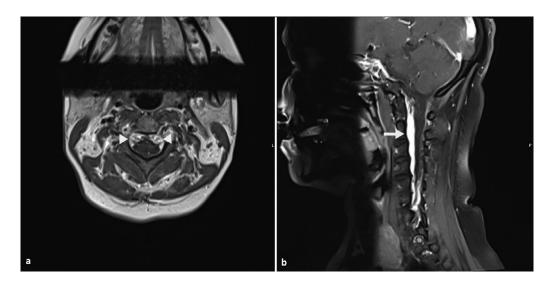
Cervical spine MRI T1 with contrast (A) axial section showing intensely enhancing process at the ventral aspect of cervical spine cord at level of C2 (arrow heads). (B) Sagittal demonstrates the enhancing process at the ventral aspect of the canal extending from the odontoid process through the inferior C5 level (arrow). The process also appears to extend along the posterior aspect of the clivus.
